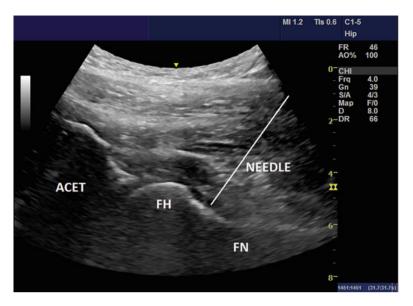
Ultrasound image of intra-articular hip injection (needle enhanced for clarity). Legend: *ACET* acetabulum, *FH* femoral head, *FN* femoral neck
